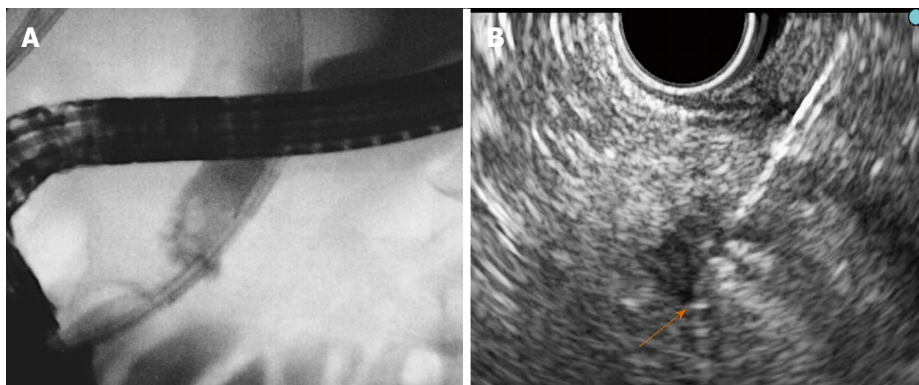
Endobiliary and pancreatic radiofrequency ablation. A: Fluoroscopy: The Habib TM EndoHBP inside the common bile duct; B: EUS: The EUSRA RF electrode (STARmed) inserted in a PNET. Tip of the probe (orange arrow). EUS: Endoscopic ultrasonography; RF: Radiofrequency.
